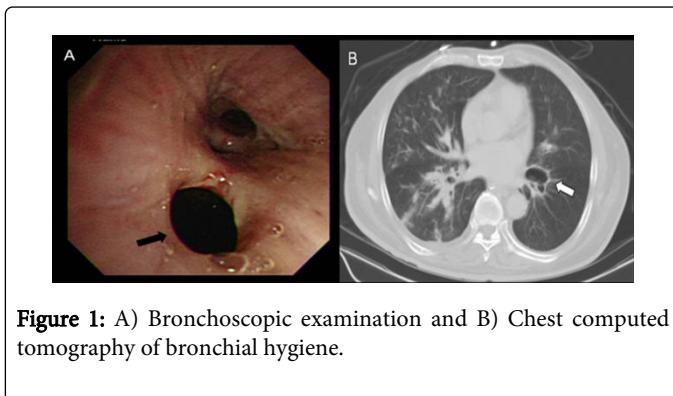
A) Bronchoscopic examination and B) Chest computed tomography of bronchial hygiene.
